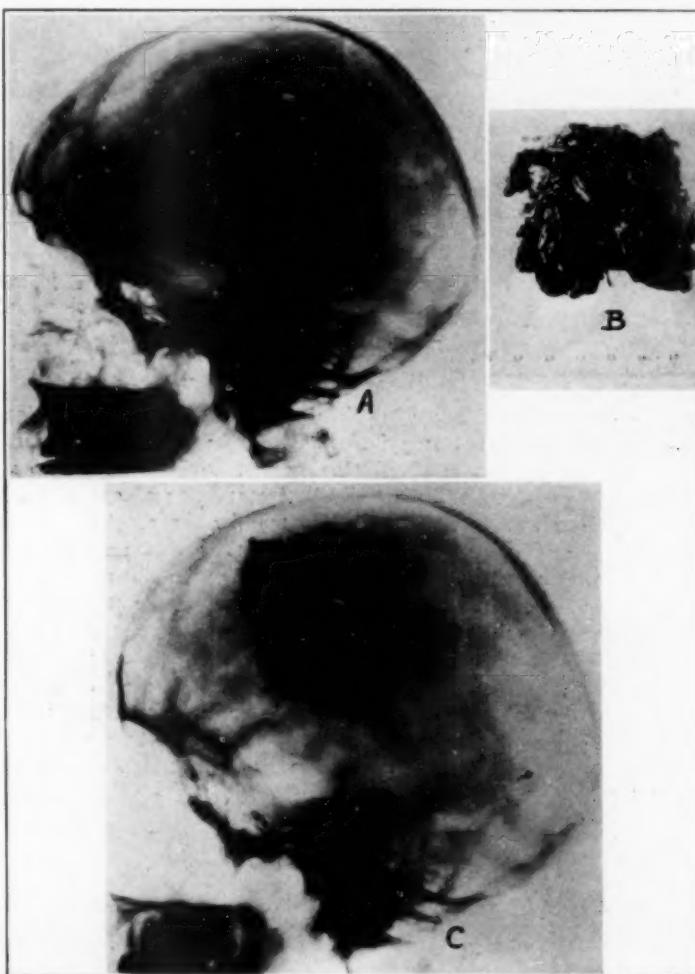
Endothelioma of left parietal lobe. Roentgenogram showing enlargement of anterior and posterior diploic veins on the left side of the skull.
